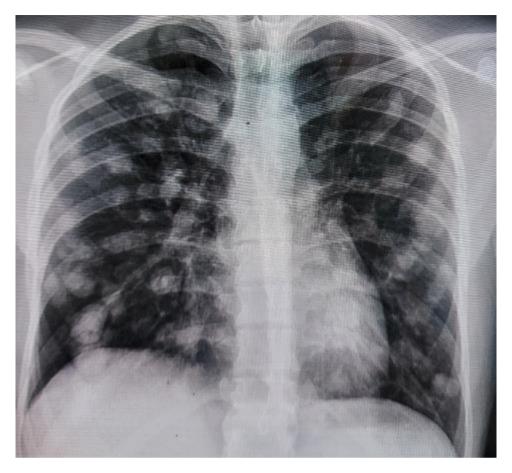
Chest Xray showing multiple suspicious images in the lungs.
